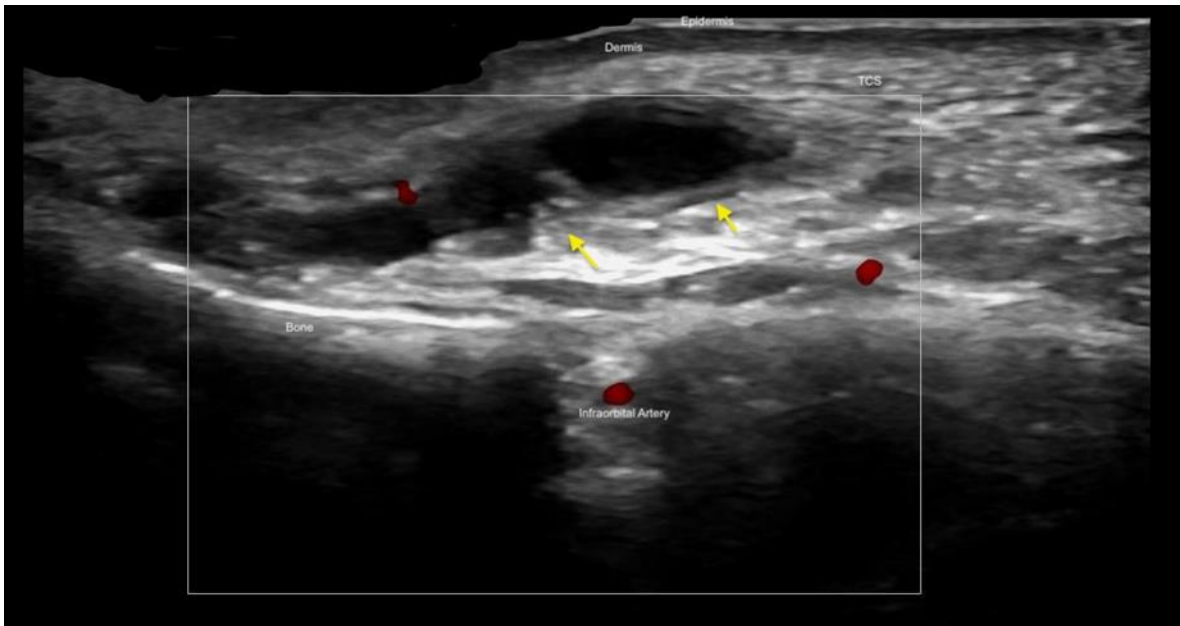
Axial grayscale image. Displays a deposit of hyaluronic acid with pseudosolidification changes located in the infraorbital region; it feels firm to the touch. The arrow shows hyaluronic acid deposits with oval, confluent, pseudocystic images without degradation changes, with a hyperechoic band inside the periphery of the deposits, corresponding to pseudosolidification changes. Doppler examination shows no increased vascularity, distinguishing it from nodules termed 'Red Angry Bump.'
